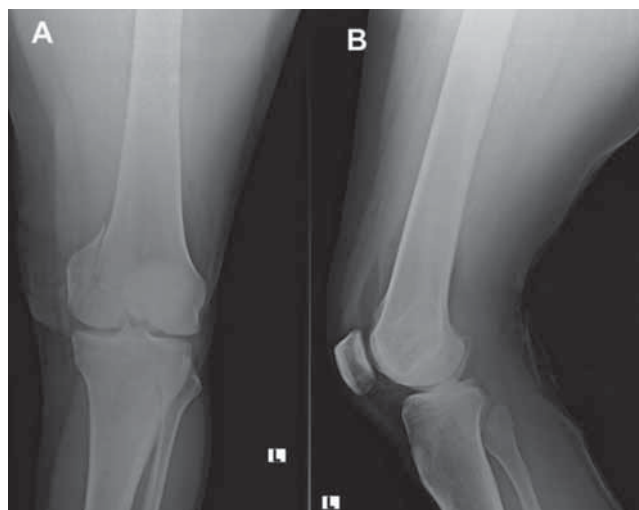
Radiographs of the left knee taken upon admission and showing an atypical intra-articular fracture in the distal femur: (A) anteroposterior view; (B) lateral view.
